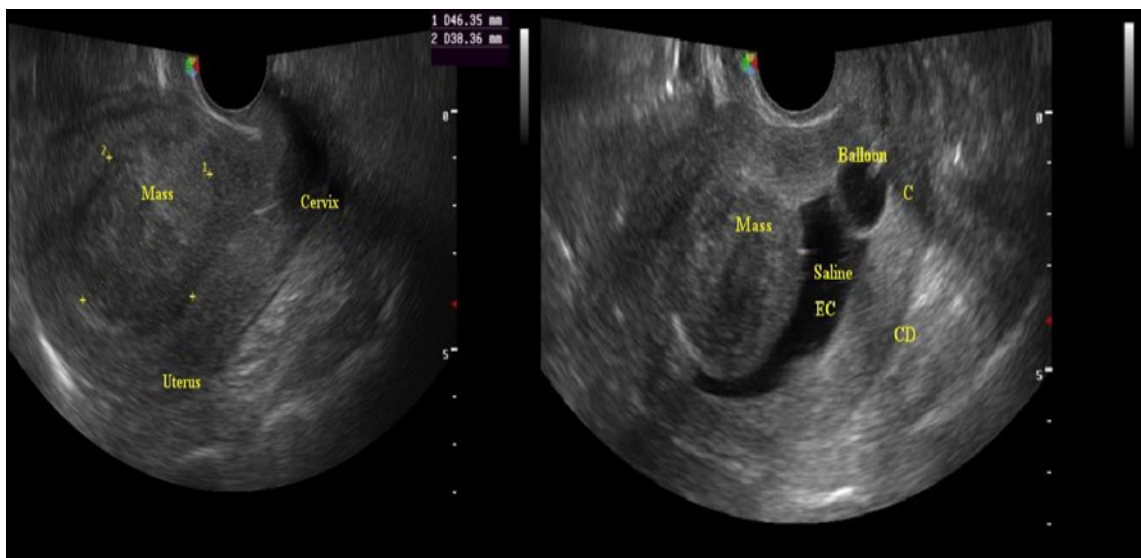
Transvaginal sonogram showing large broad-base submucous myoma with bilateral tubal blockage in a 38-year-old patient with secondary infertility.:
